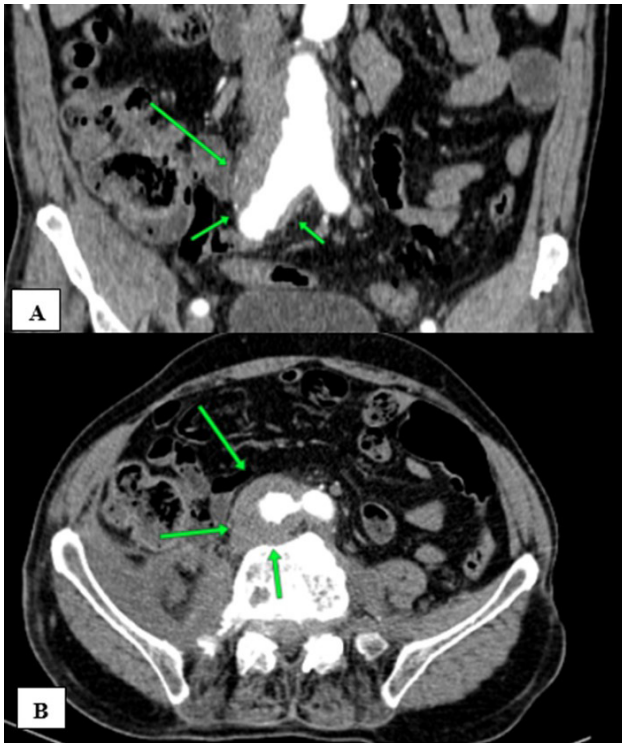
(A-B) axial and coronal contrast-enhanced CT, in the arterial phase, showing as additional finding a fusiform abdominal aorta aneurysm with extension to the right iliac artery.
